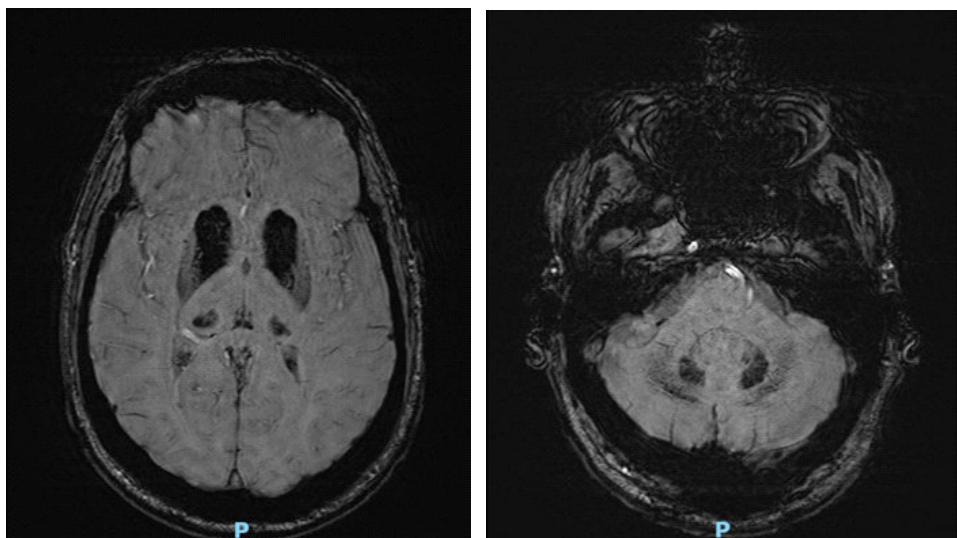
Axial SWI brain MRI sequences.
